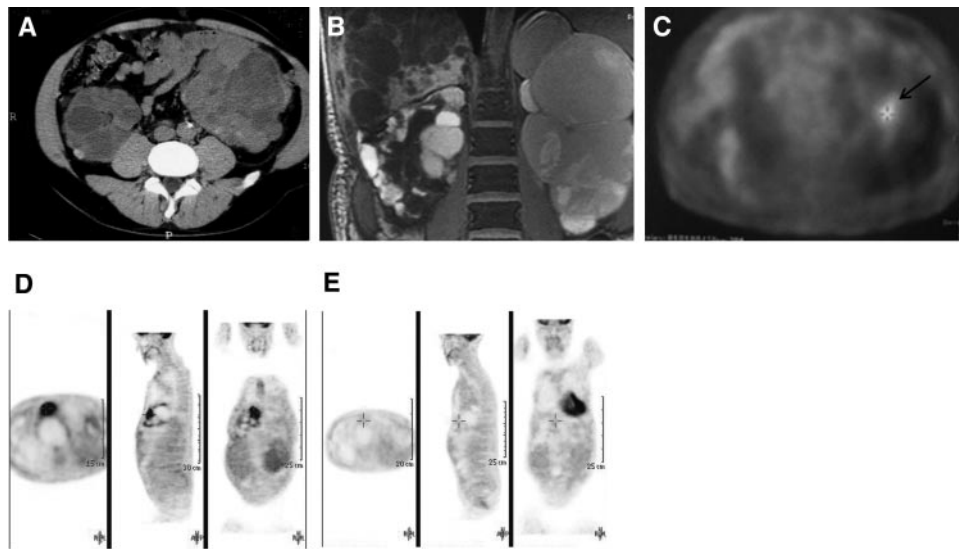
A 53-yr-old man with autosomal dominant polycystic kidney disease (ADPKD) and chronic kidney disease (GFR 30 ml/min per 1.73 m²) presented with fever, abdominal pain (upper left quadrant), and increased serum C-reactive protein level. A left kidney cyst infection was suspected. (A through C) A nonenhanced computed tomography (CT) scan (A) and magnetic resonance imaging (T2-weighted sequence; B) disclosed several renal cysts with variable fluid density in the absence of overt signs of cyst infection; however, a positron emission tomography (PET) scan (C) showed an area of increased FDG uptake (arrow) highly suggestive of ongoing infection in a left kidney cyst. (D) A 62-yr-old woman who had ADPKD and was undergoing hemodialysis (patient 6) was admitted for fever and abdominal pain (upper right quadrant). Blood cultures grew positive for *Escherichia coli*. Abdominal CT scan was inconclusive. A PET scan disclosed an ongoing infection in a liver cyst (arrow). (E) A control PET scan performed 1 mo after antibiotherapy (ciprofloxacin) showed the resolution of cyst infection (dashed arrow). Positive signal on the last frame occurs in the heart.
